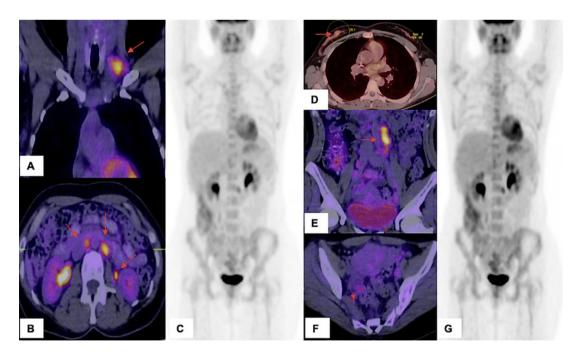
Combined 2-[¹⁸F]-fluoro-2-deoxy-D-glucose positron emission tomography/computed tomography showed: increased uptake in retroperitoneal and left supraclavicular lymphadenopathy (A, B, arrows); partial response with chemotherapy (C); progression of the disease with retroperitoneal and right iliac lymphadenopathy, as well as evidence of a right breast tumor (D–F, arrows); and a complete response to second-line chemotherapy (G).
